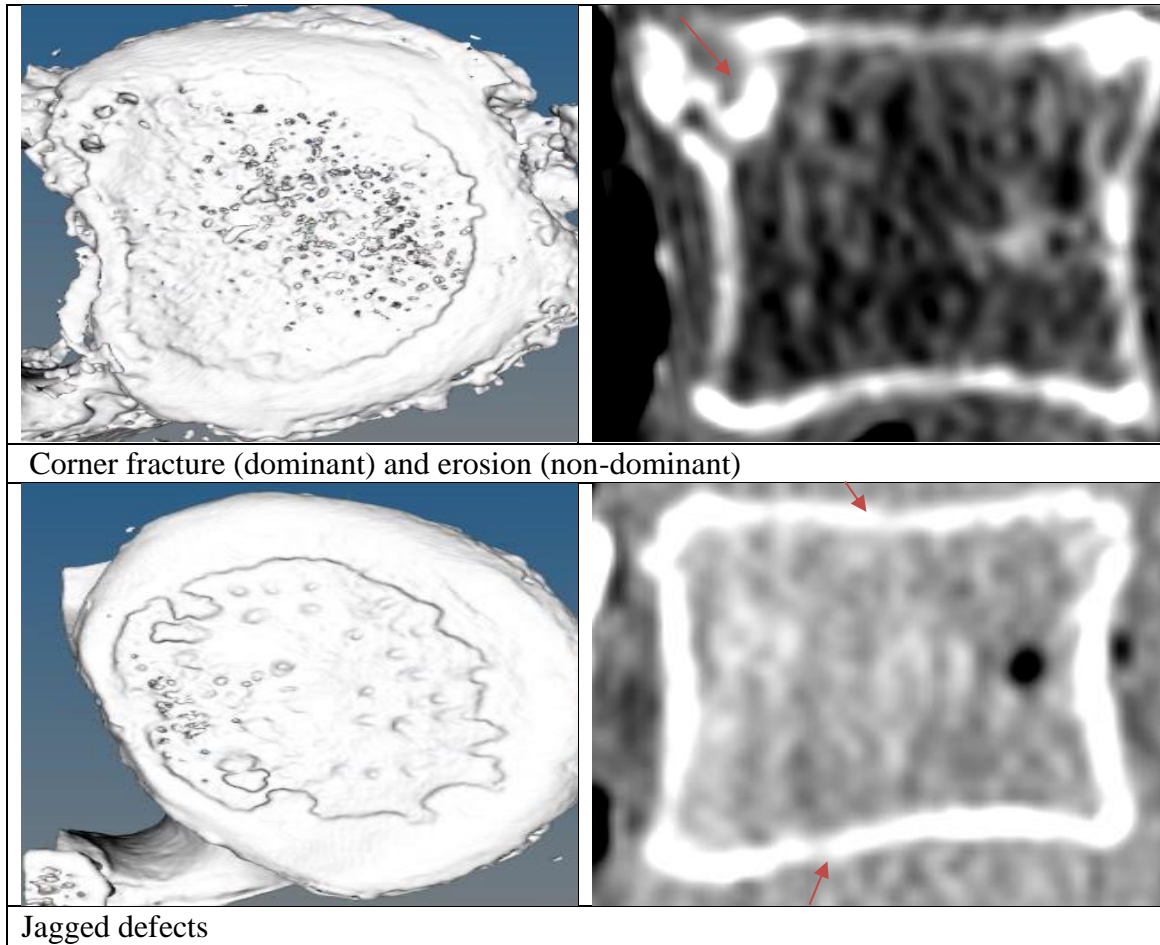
EPSP phenotypes observed on μ CT and corresponding CT
